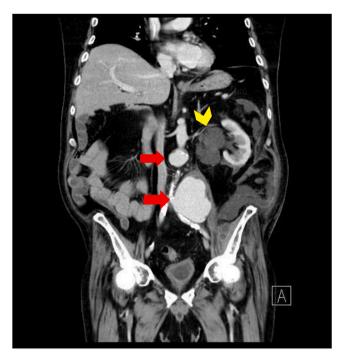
Abdominal CT show two large aneurisms (red arrows) located on the left intrarenal aortic and the other one on the left common iliac artery, both with suggestive signs of rupture. Renal artery abscess is also shown (yellow arrow), associated with surrounding inflammation.
